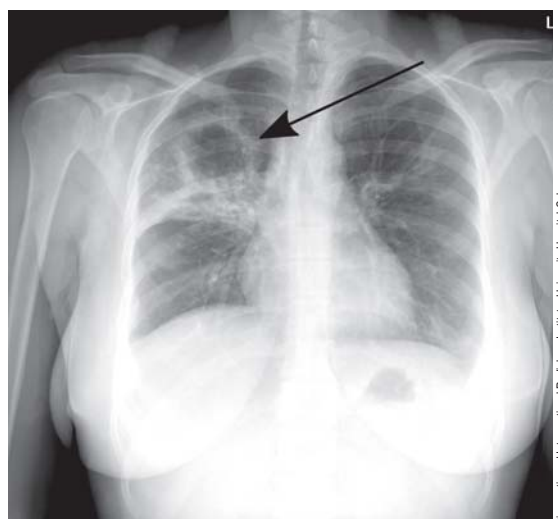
Pulmonary tuberculosis with a large cavity (arrow) in the upper field of the right lung (chest radiograph, p.a. view)
